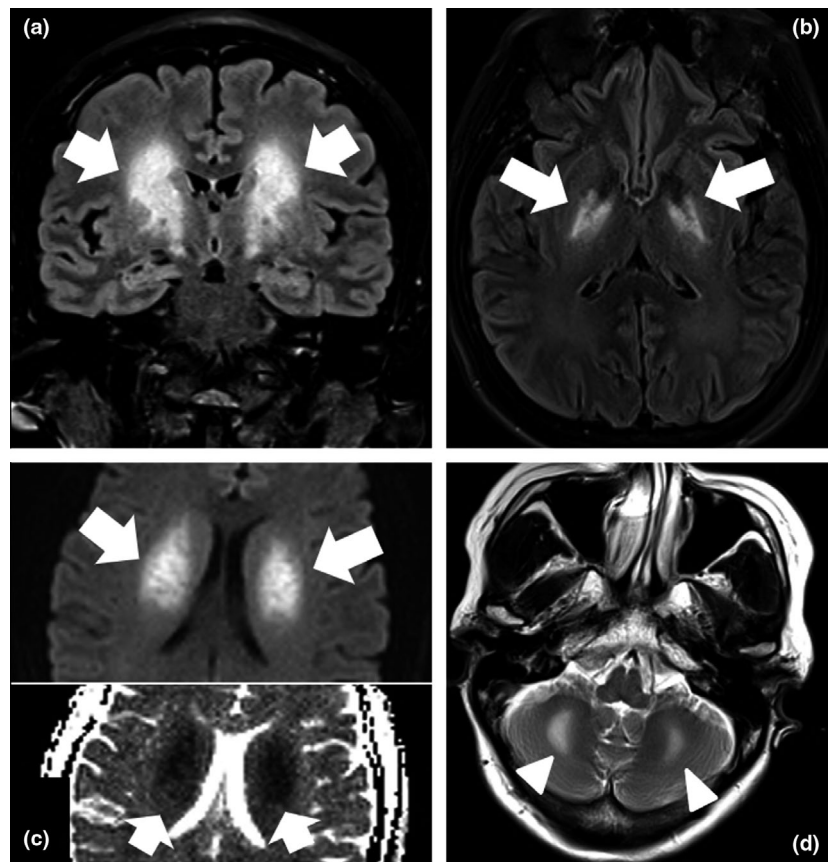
Brain magnetic resonance imaging (MRI) findings. Coronal FLAIR (a), axial FLAIR (b) and diffusion (c) and axial T2 (d) weighted sequences of brain MRI. T2-FLAIR hyperintensity, restricted diffusion and swelling of bilateral globus pallidus and deep white matter are present extending symmetrically along both semioval centra and anterior limbs of internal capsules (arrows), and also over both cerebellar hemispheres (arrowheads). Findings are consistent with a toxic-metabolic encephalopathy
